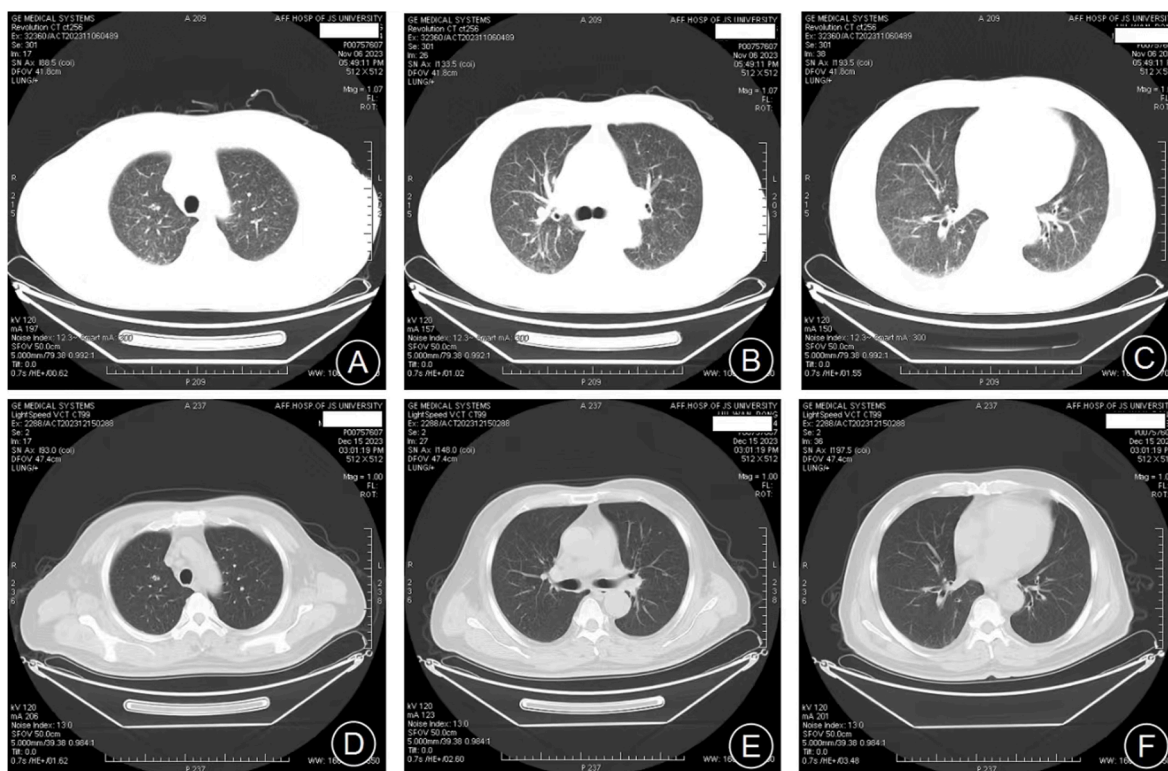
The computed tomography (CT) of case one pre-treated (A–C) and pro-treated (D–F) with Voriconazole at different levels. After one-month treatment, the lesions were absorbed obviously.
